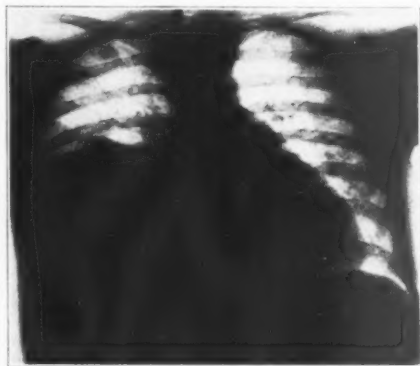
Roentgenogram taken before second operation.
